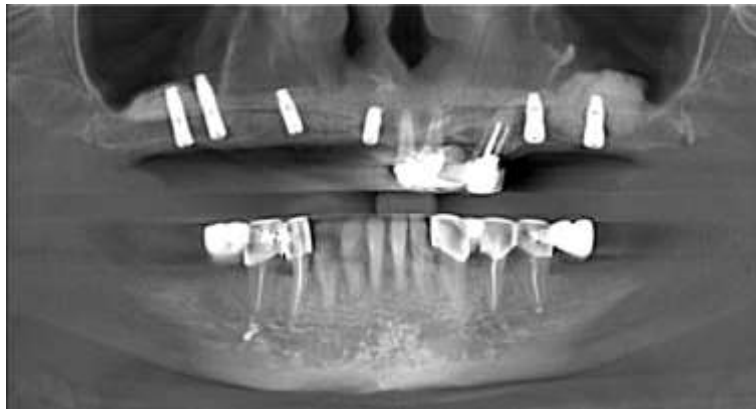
Cone beam computed tomography of the upper and lower jaw. In the distal parts of the upper jaw, a sinus lifting operation with bone augmentation was performed. DIO implants were installed in the areas 11-13-15-16 and 25-27.
